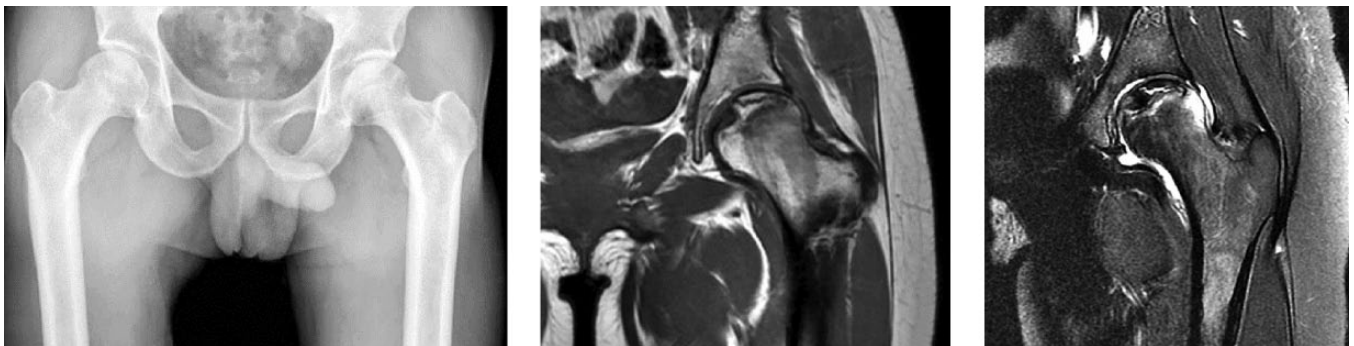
Grade I ONFH on a) plain radiograph, b) T1 and c) T2.
